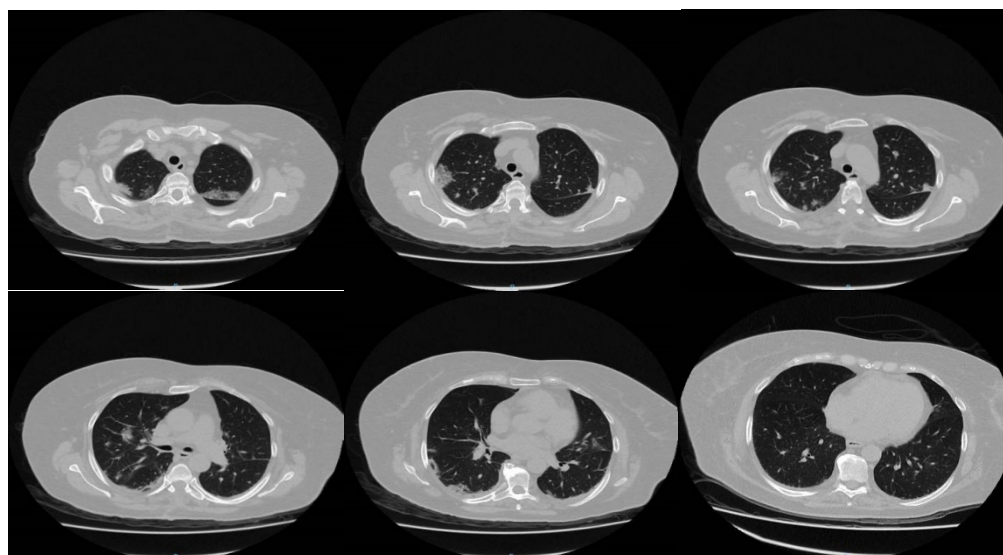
Chest CT performed 9 days after COVID-19 diagnosis reveals multilobar consolidations with positive air bronchograms, localized in the subpleural and central regions in both lungs, more frequently in the upper and lower pulmonary lobes.
